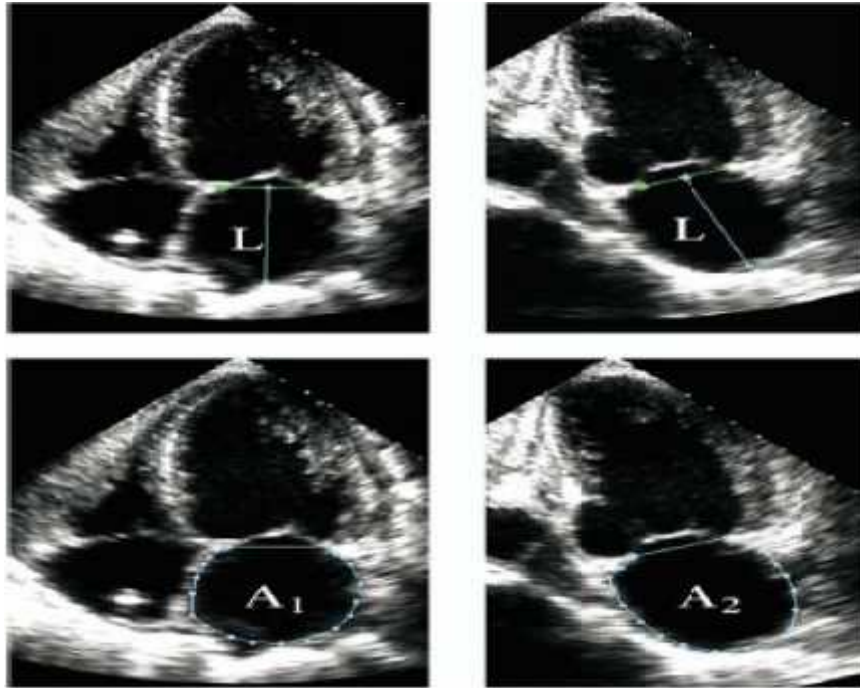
Measurement of left atrial (LA) volume from area-length (L) method using apical 4-chamber ($A4C$) and apical 2-chamber ($A2C$) views at ventricular end systole (maximum LA size). L is measured from back wall to line across hinge points of mitral valve. Shorter L from either $A4C$ or $A2C$ is used in equation
